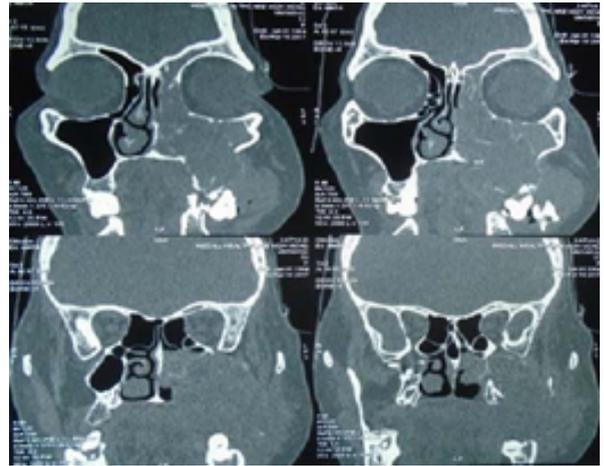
CT Scan Showing Mass In The Left Maxillary Sinus Of Chondrosarcoma Case
